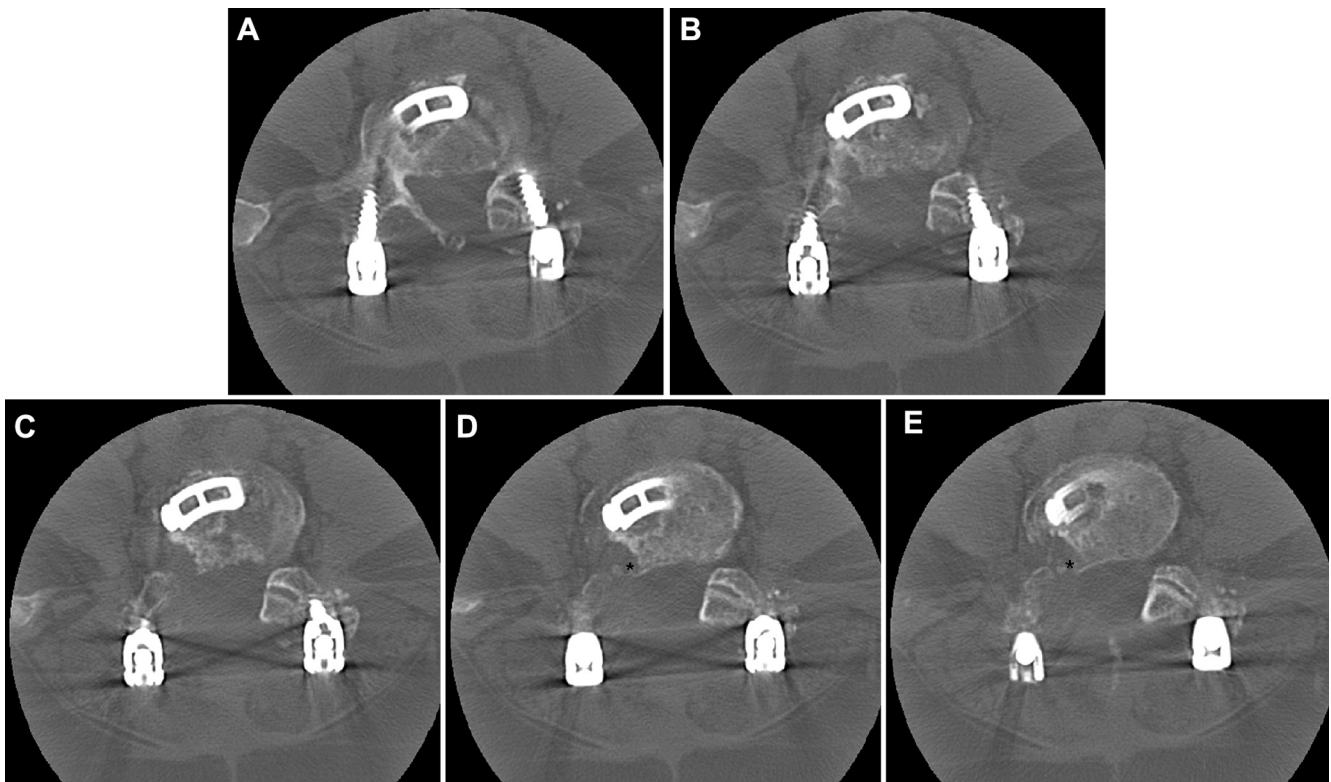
Axial computed tomography scan images through the L4–L5 level demonstrating heterotopic ossification in the right neuroforamina moving cranially from the L5 pedicle (A–E). Asterisks denote bone/tissue formation near prior annulotomy that is compressing the exiting nerve root.
